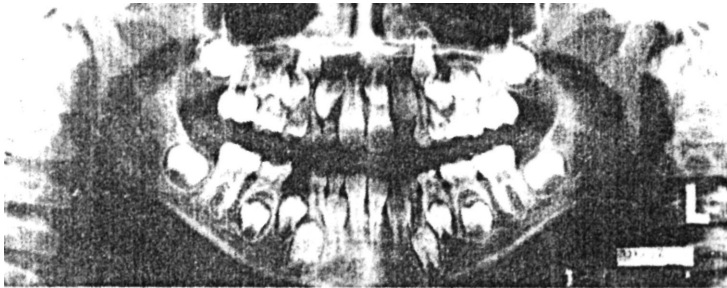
Orthopantomograph of all upper and lower teeth.
